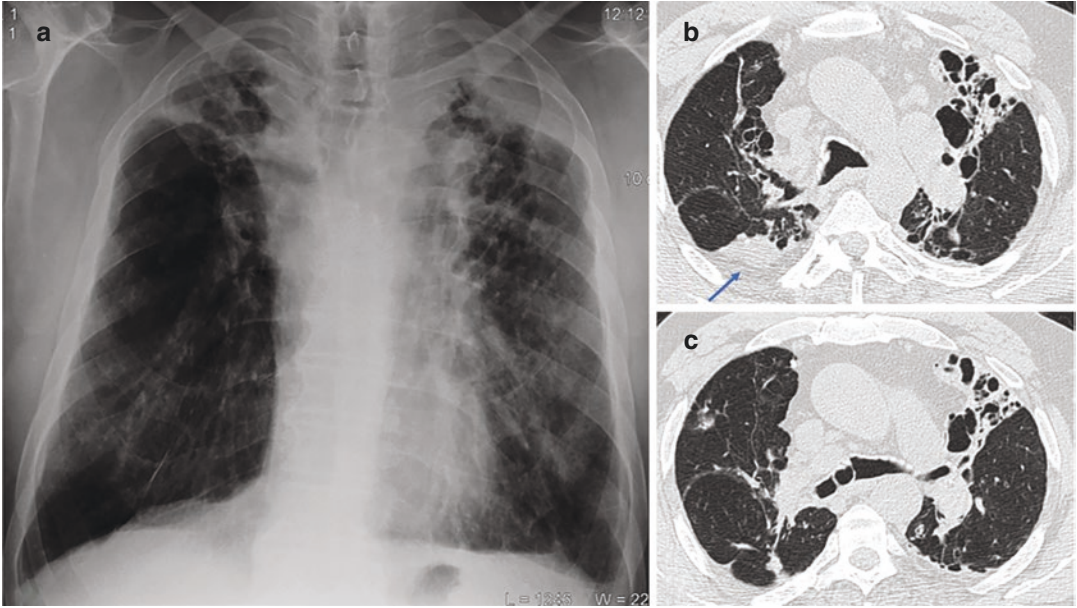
Tuberculosis sequelae. (a) PA chest radiograph shows retractor bilaterally apical opacities with bilateral hilar elevation. (b and c) Axial HRCT images show
